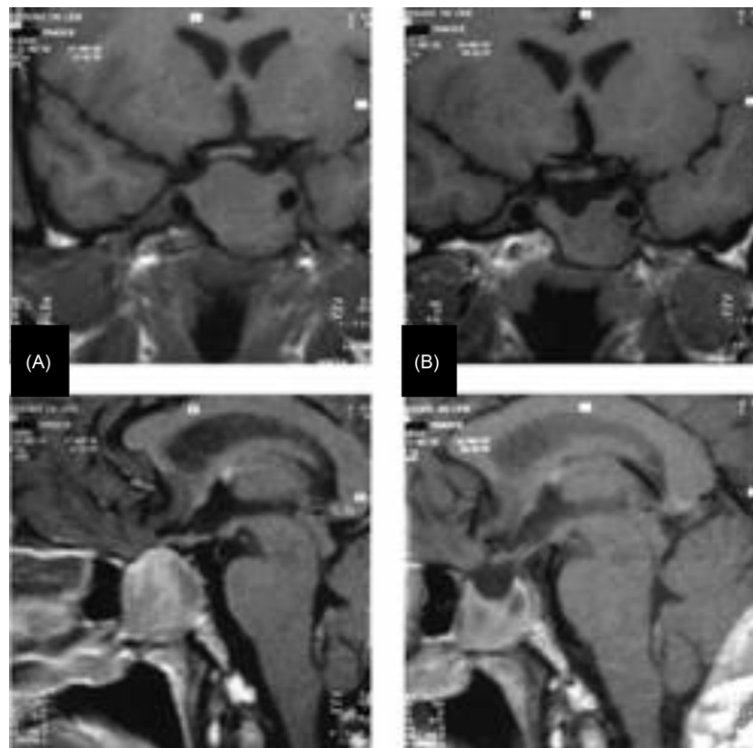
Effect of treatment with first generation somatostatin analogue on tumor volume as assessed by MRI. (A) Before treatment; (B) after 3 months of treatment with somatostatin analogues. Upper panels, coronal view; lower panels, sagittal views.
